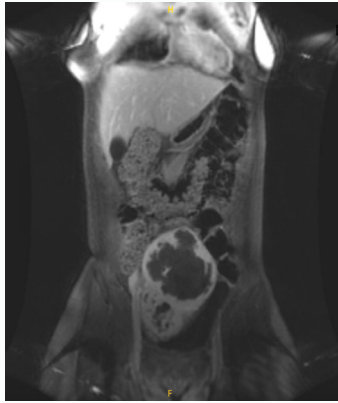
Hydronephrosis of the right kidney seen on MRI.
